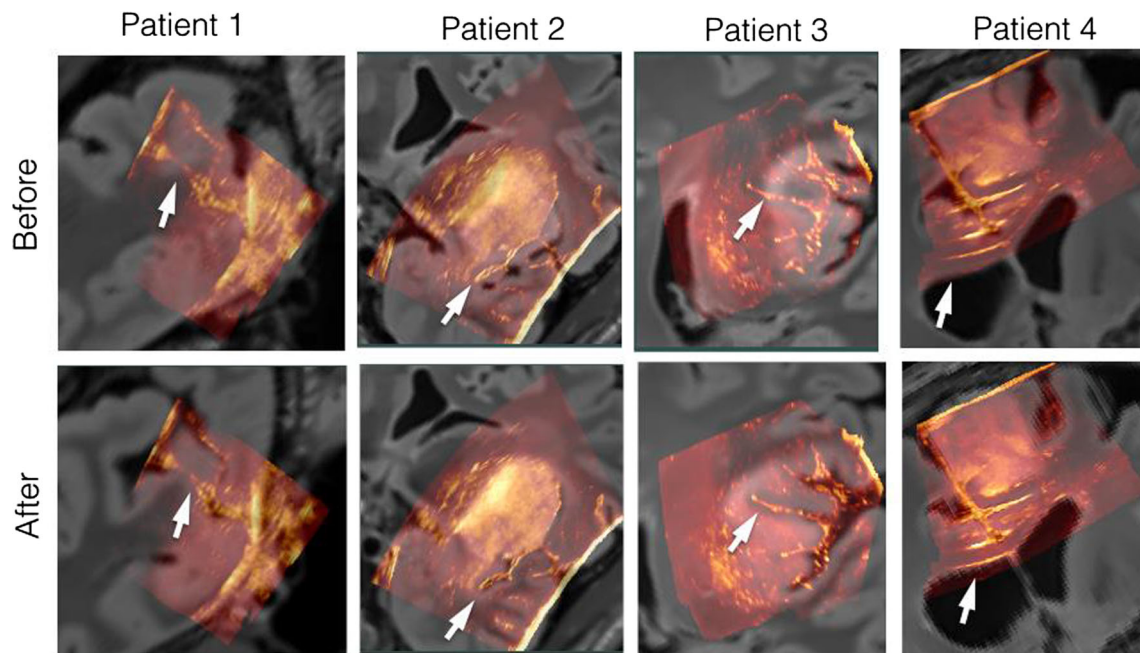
Comparison of image alignments before and after nonlinear MRI-US registration for all cases. The first and second row shows ultrasound scans overlaid upon the corresponding MR images before
